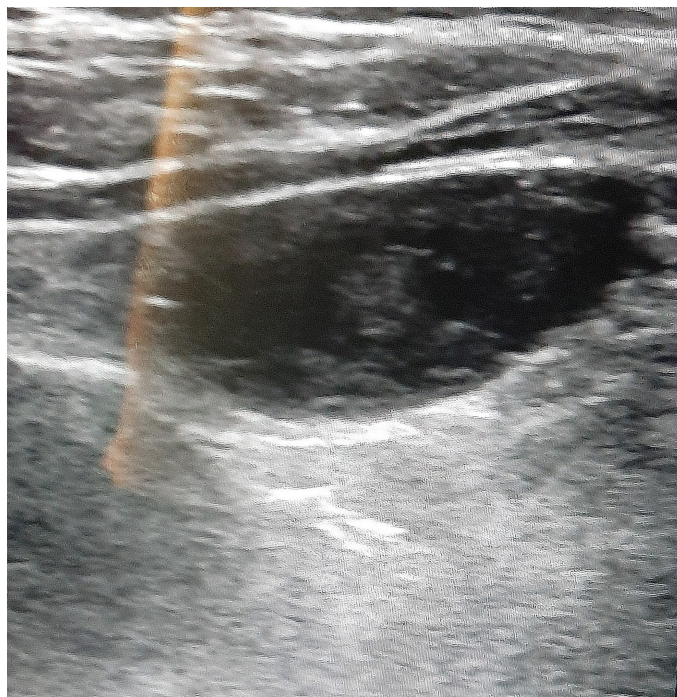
Ultrasonography image of parathyroid adenoma.
